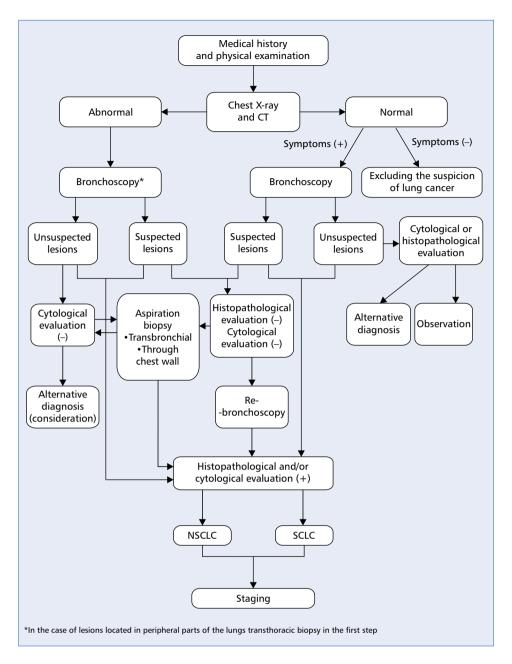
Principles of diagnostic procedures in lung cancer. CT — computed tomography; NSCLC — non-small cell lung cancer; SCLC — small cell lung cancer
